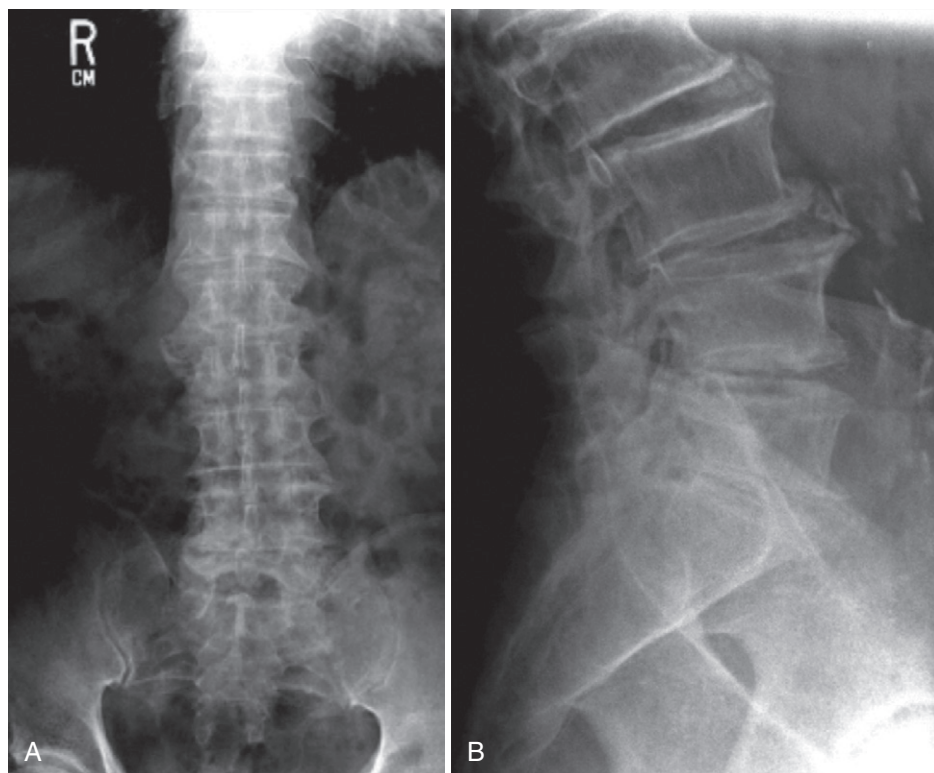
Lumbar spondylosis. Anteroposterior (A) and lateral (B) radiographs of the lumbar spine show the cardinal features of disk-space narrowing, marginal osteophytes, and end plate sclerosis. (Courtesy Dr. John Crues, University of California, San Diego.)
